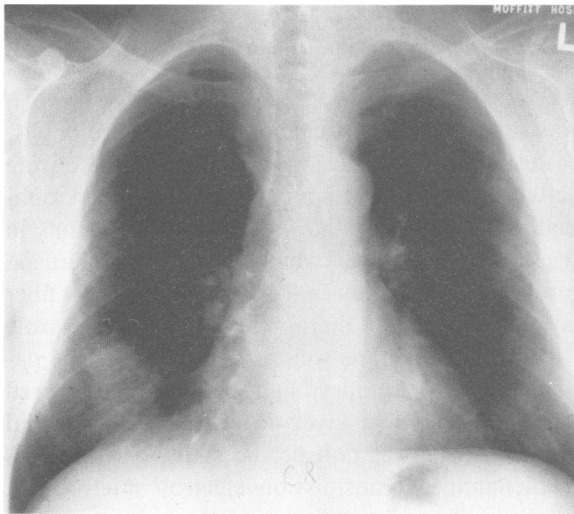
X-ray study of the chest of a renal transplant patient with a localized infiltrate that proved to be *Pneumocystis carinii* on bronchoscopy.
